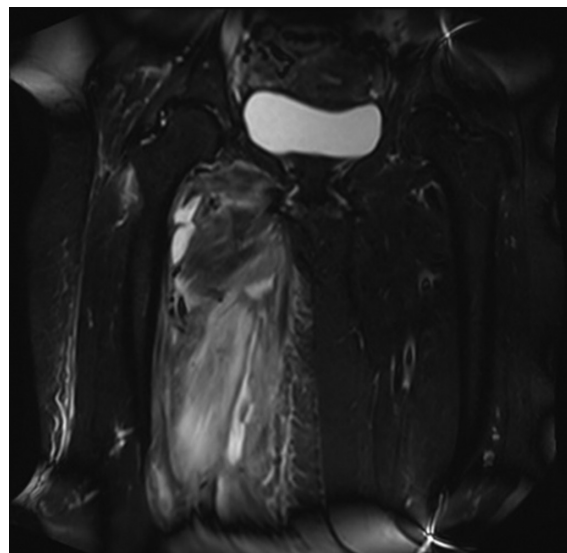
Coronal fat-suppressed T2-weighted magnetic resonance imaging of the right thigh showing diffuse muscle enlargement, loss of intramuscular fat strands, and hyperintensities (edema) in the adductor muscles. The femoral bone intensity is normal.
